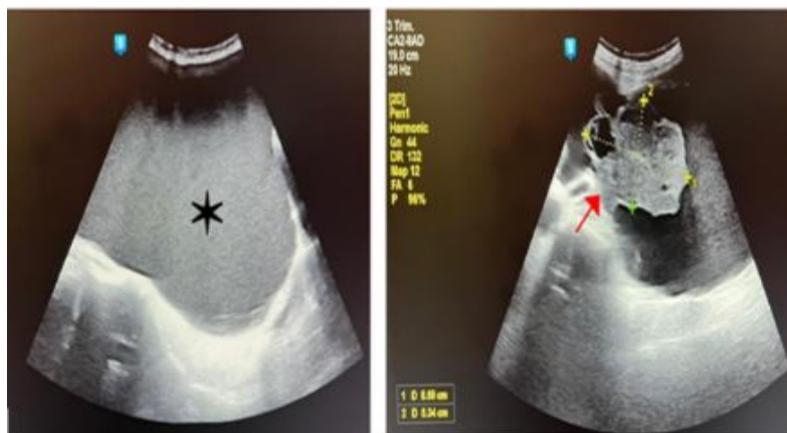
Ultrasound images showing large cystic mass with echogenic material within (*), and a hyperechoic solid component (red arrow) within the mass.
